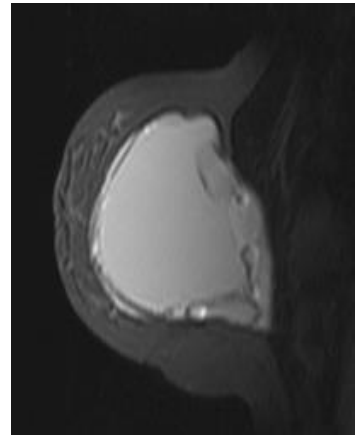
View of the ruptured implant in the left breast on a sagittal water-suppressed STIR-T2-weighted image
